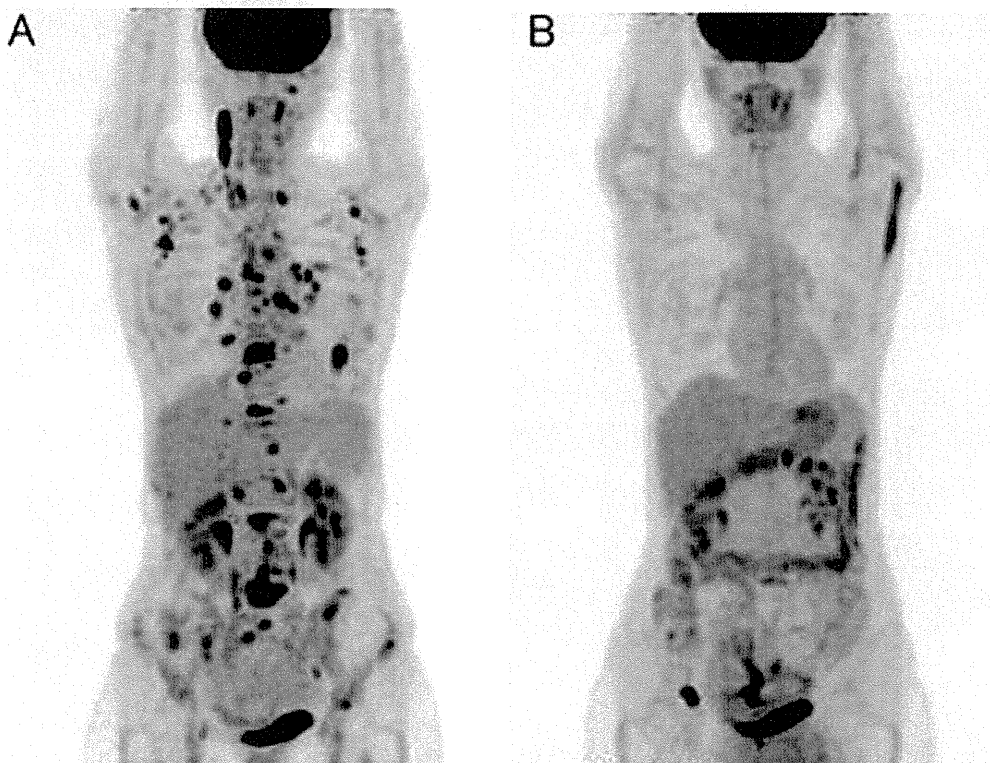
FDG-PET scan (Case 2): A, 07/22/2009 (before ALK inhibitor) and B, 03/10/2010 FDG-PET scan shows marked reduction of accumulation in multiple bone and lymph node metastases 7 months after the initiation of the treatment.
